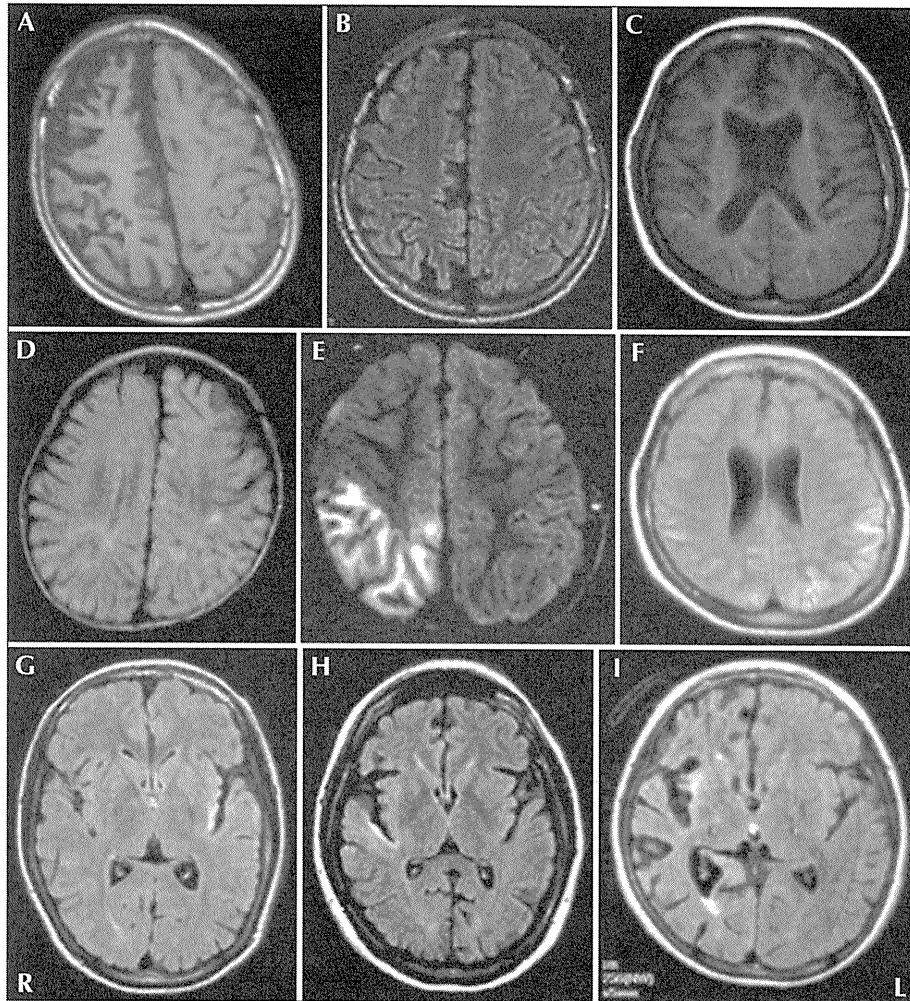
Typical MRI demonstrating atrophic lesions (ALs) and high intensity lesions (HILs).
